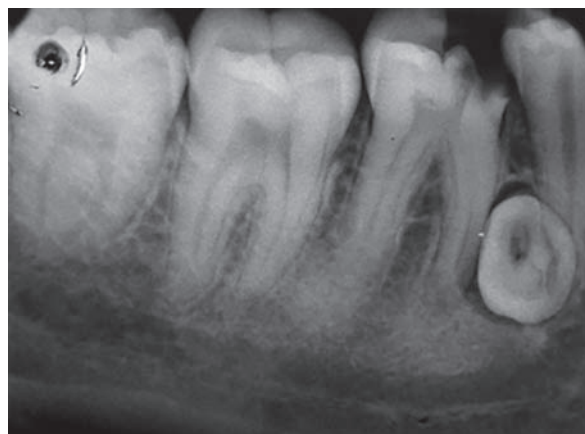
X-ray of lower right first mandibular molar showing deep carious lesion along with incompletely developed supernumerary tooth
